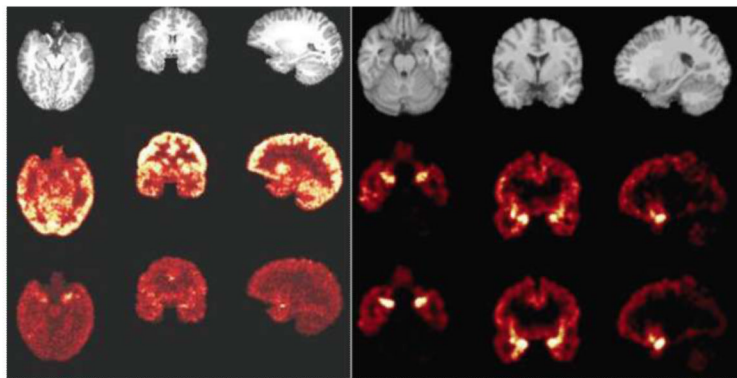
MRI scans and positron emission tomography (PET) images of kappa opiate receptors in the brain of a healthy individual. For both left and right panels, the left column shows the axial slice, the middle column shows the coronal slice and the right column shows the sagittal slice. The PET images of the receptors confirm their known distribution in the human brain, with high levels in a circuit implicated in post-traumatic stress disorder, which includes the amygdala, hippocampus and ventromedial prefrontal cortex. Left panel: *Top row:* MRI images. *Middle row:* 0–10 min summed PET image. *Bottom row:* 60–120 min summed PET image. Right panel: *Top row:* MRI images. *Middle row:* corresponding binding potential (BPND) images estimated using a simplified reference tissue model [SRTM]). *Bottom row:* corresponding BPND images estimated using the SRTM2; it is slightly less noisy than the SRTM, as would be expected.
